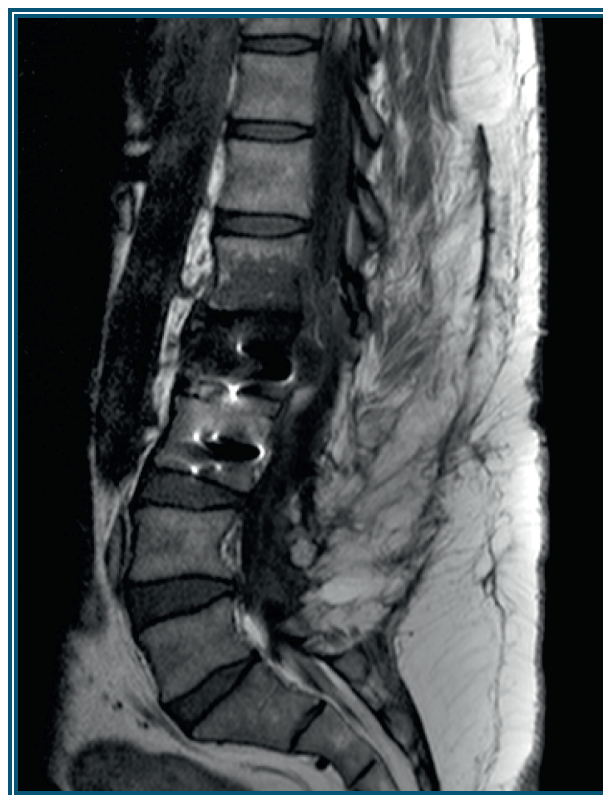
Magnetic resonance imaging of hydatid disease in L4 and L5 vertebrae.
